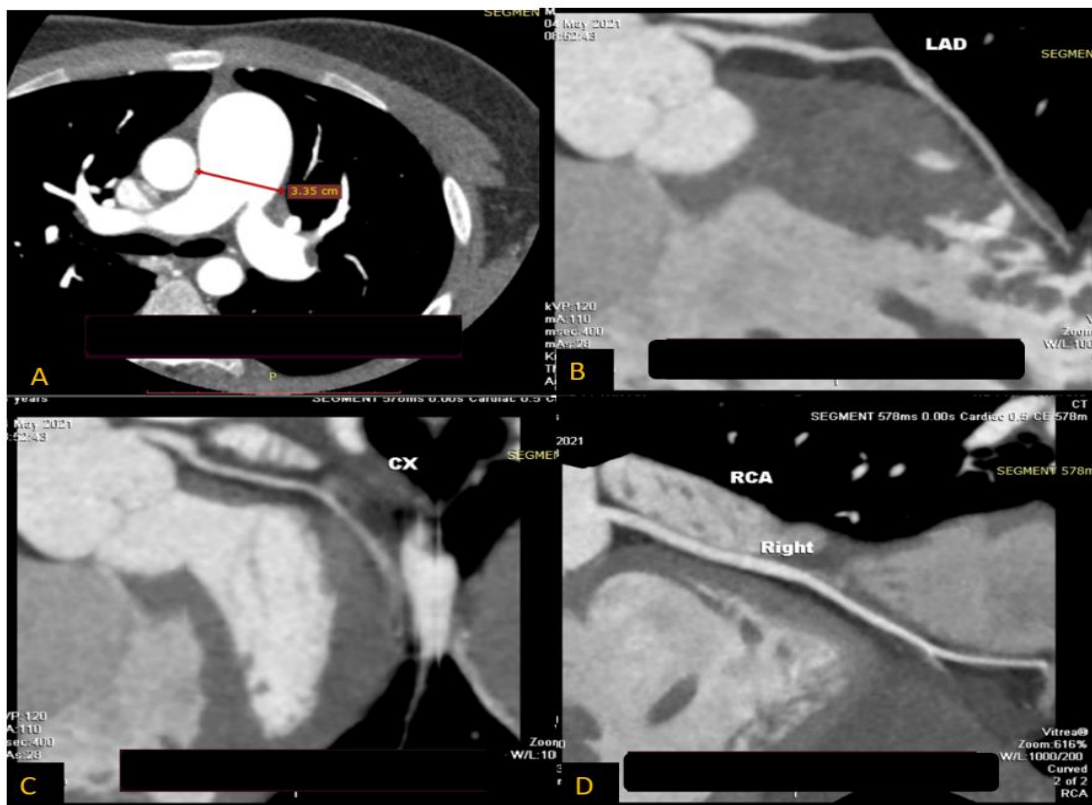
CT angiography showed dilatation of pulmonary artery and right pulmonary artery looks stenosed (figure 4a), and no obstructive coronary artery disease in left main – left anterior descending (figure 4b), left circumflex (figure 4c), and right coronary artery (figure 4d).
